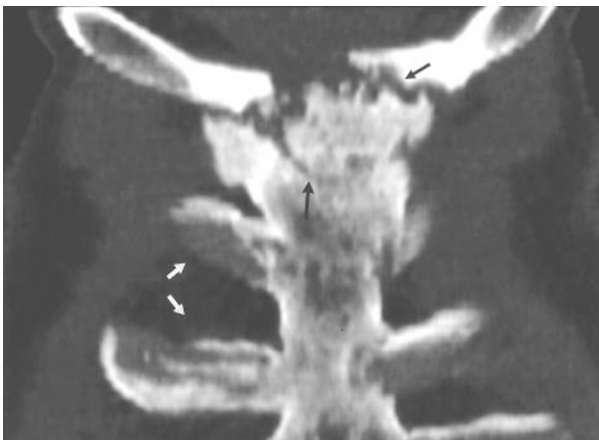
Coronal reformatted computed tomography of the sterno-costoclavicular joints showing severe arthro-osteitis of the sternoclavicular joints (small black arrow), hyperostosis of the costosternal joints (white arrows) and an oblique fracture through the manubrium (large black arrow)
